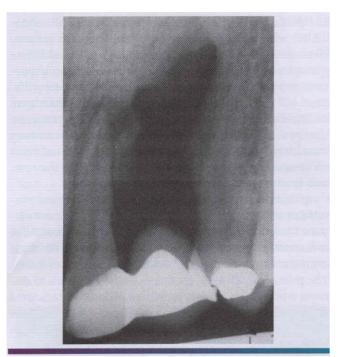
• Periapical fibrous scar. Periapical radiolucency of maxilla at the previous site of extraction in which both cortical plates were lost. The site was filled with dense collage nous tissue. (Courtesy of Dr. James Tankersley.)
